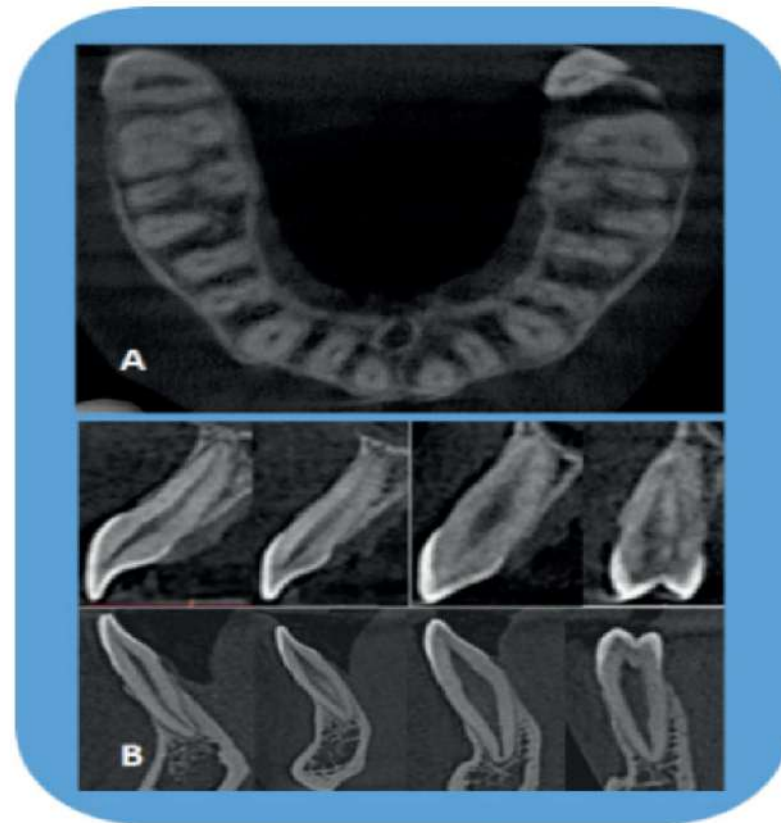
CBCT images (axial and crosssections) are indispensable in endodontics for the evaluation of morphology of the tooth including location and number of canals, pulp chamber size and degree of calcification, root structure, direction and curvature, fractures, iatrogenic defects, and the extent of dental caries. The images also allow measurements free from distortion and magnification.
